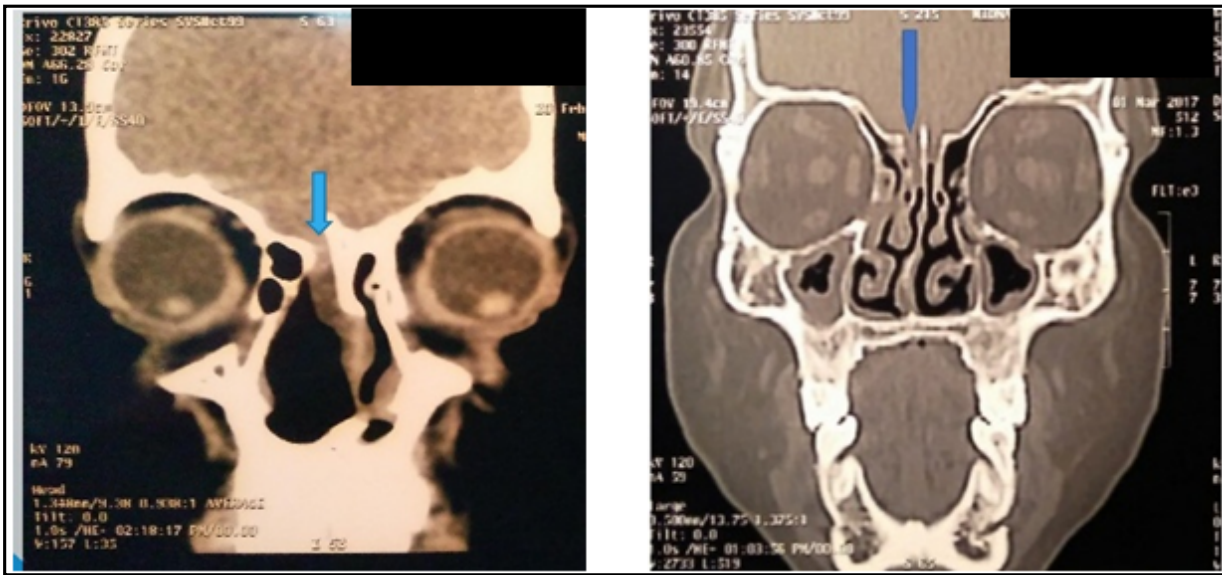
Representative HRCT PNS images showing medial lamellar leak in two different patients.
